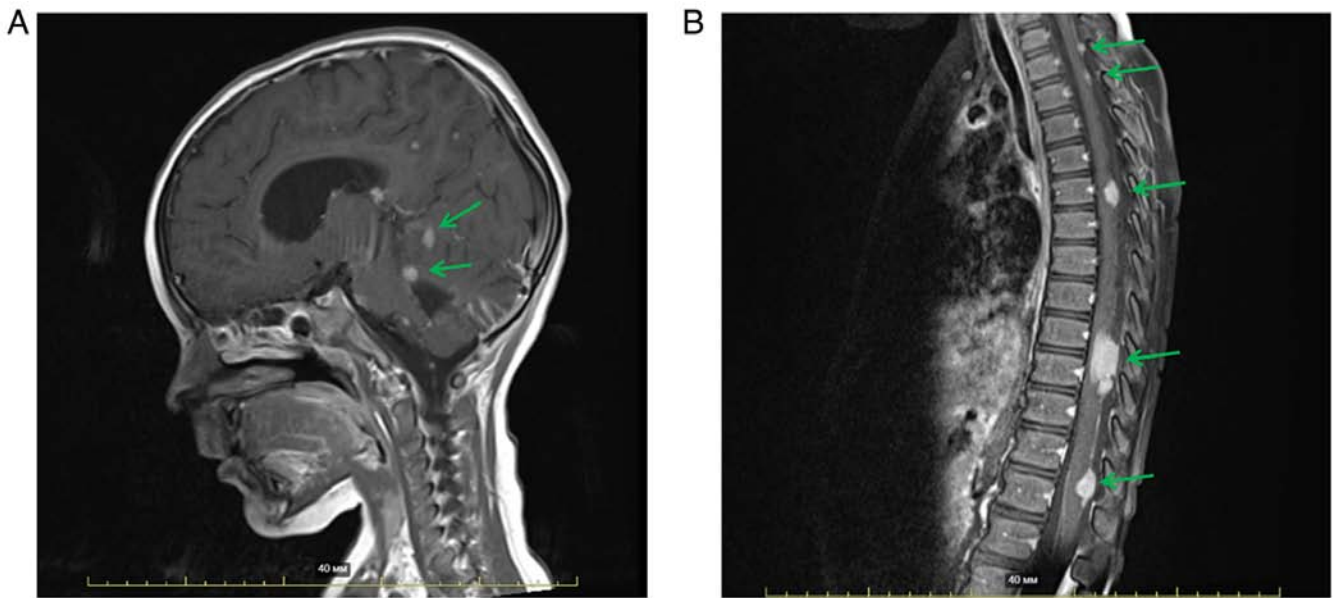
Central nervous system MRI of the patient performed at 4 weeks after the surgery. (A) Brain MRI (Sag T1 SE + C). Diffuse infiltration of the meninges of the cerebral hemispheres in the area of the interpeduncular cistern was observed with intensive contrast enhancement (green arrows; scale bar, 40 mm). (B) Spinal cord MRI (Sag T1 TSE + C). Multiple metastatic lesions of the meninges of the spinal cord (Th5, Th9-Th10, Th12-L1) and signs of spinal compression at the level of Th9-Th10 were observed with intense contrast enhancement (green arrows; scale bar, 40 mm). Sag, sagittal.
